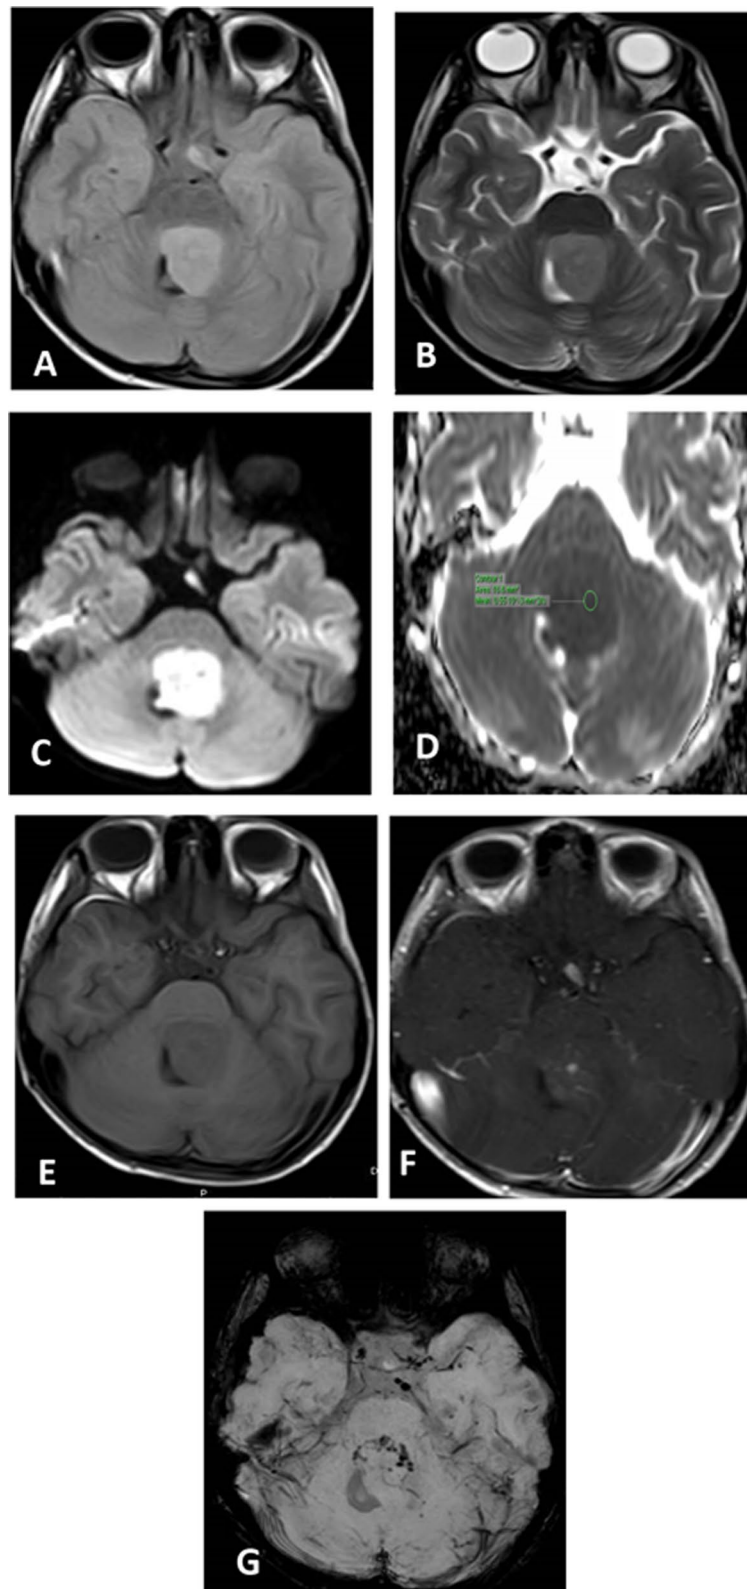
A 10-year-old male child with posterior fossa medulloblastoma. A Axial FLAIR and B T2 WI show mass in the fourth ventricle of high signal. C Axial DWI and D ADC show diffusion restriction with low ADC value measuring $0.55 \times 10^{-3} \text{ mm}^2/\text{s}$. E Axial pre-contrast T1 WI shows low signal. F Axial post-contrast T1 WI shows mild enhancement. G SWI shows more than 10 foci of hypointense signal (ITSS score 2)
